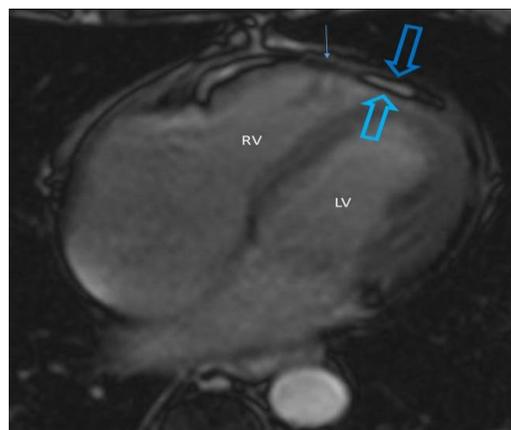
Constrictive pericarditis on MRI [30]
